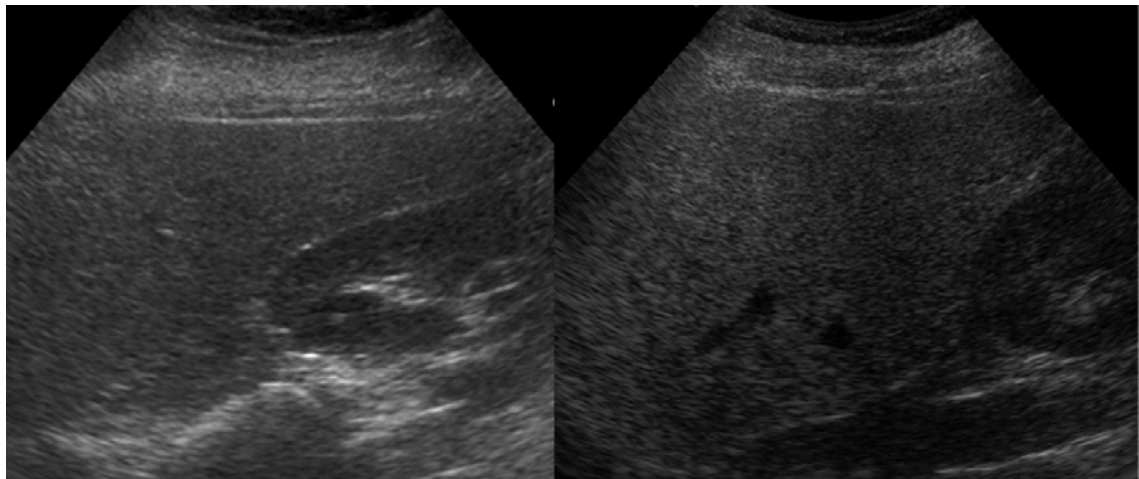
Conventional gray scale ultrasound liver images with appearance of normal liver.
